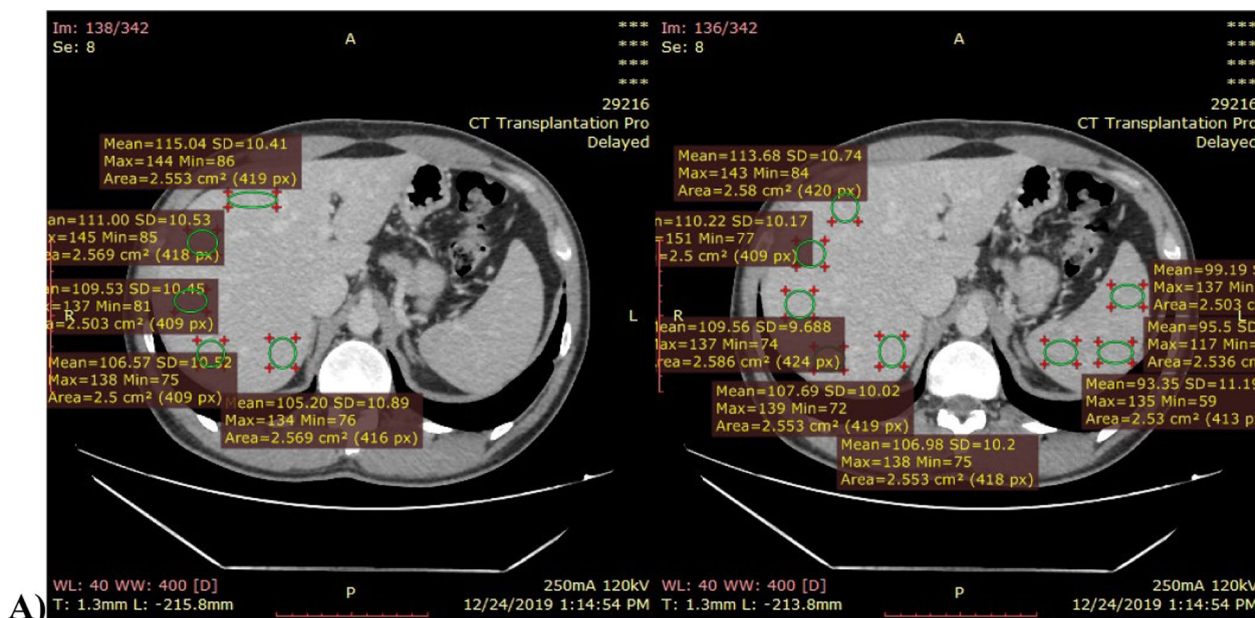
A 35-year-old man patient seeking orthotopic living donor liver surgery. Traditional abdominal imaging and laboratory findings from his original assessment indicate that there is no discernible steatosis. CT transplantation protocol was done with assessment of LAI which was done in delayed phase showed (LAD= 12.2), which according to our cutoff value result of 9, suspected steatosis is 0–10%. Fibroscan study was done, and assessment of CAP showed CAP = 162 db/m, which keep with SO grade that equals to 0–10% steatosis. Liver biopsy was done and showed 0% steatosis. Both LAI and CAP results are true positive to biopsy result. A CT scan. B Fibroscan
